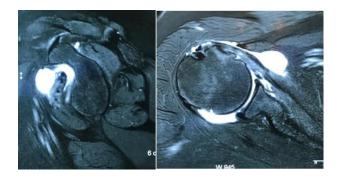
MRI images showing coracoid impingement.
